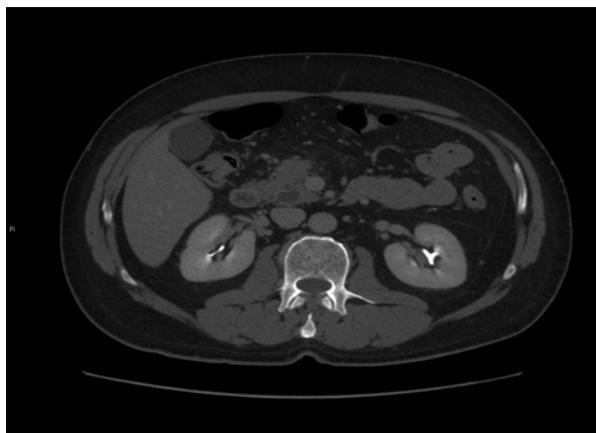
Contrast-enhanced CT scan; main-duct IPMN: presence of multiple cystic lesions at the head of the pancreas (main-duct IPMN)
